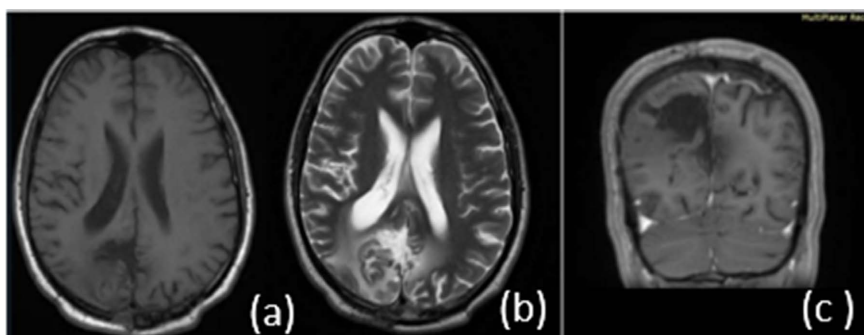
Postoperative MRI: (a) T1 axial, (b) T2 axial and (c) coronal T1 with contrast, showing complete tumor resection with no residual tumor.
